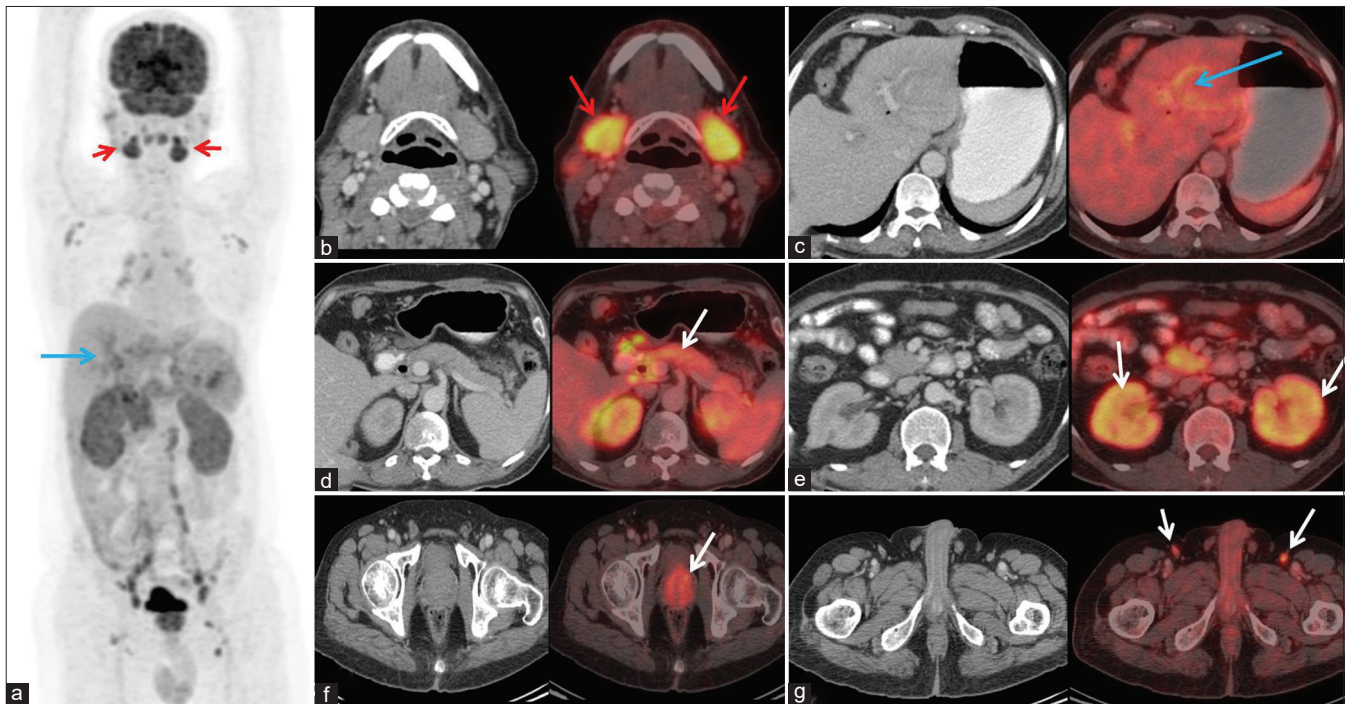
The FDG PET-CT scan showed hypermetabolism in bilateral submandibular salivary glands (red arrow marked in (a) MIP image and (b) fused PET-CT), biliary radicles (blue arrow marked in (a) MIP image and (c) fused PET-CT), pancreas (arrow marked (d)), bulky appearing bilateral kidneys (arrow marked (e)), prostate (arrow marked (f)), and multiple supra- and infradiaphragmatic lymph nodes (inguinal lymph nodes, arrow marked (g)). FDG PET-CT: Fluorodeoxyglucose positron emission tomography-computed tomography, MIP: Maximum intensity projection
